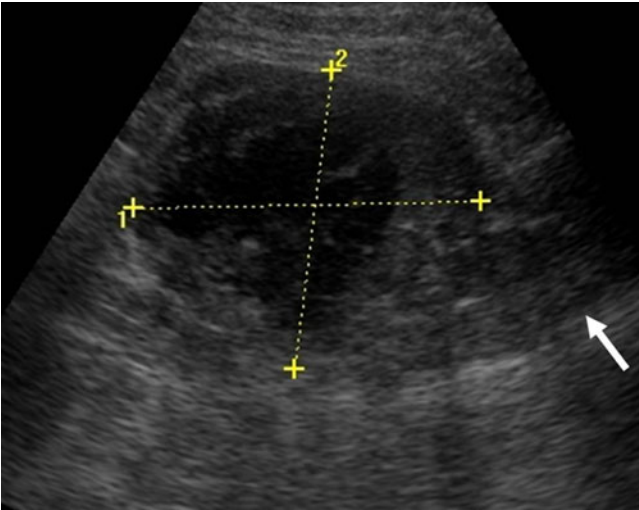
Sonographic image showing a thick walled, predominantly hypoechoic collection (callipers) seen adjacent to the transplanted pancreas (*white arrow*).
